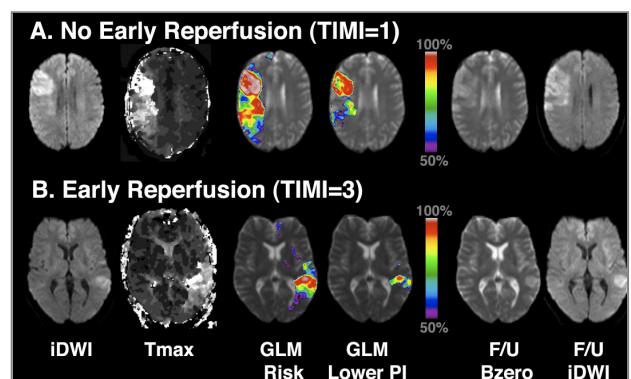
Example input and output GLM maps for patients receiving rt-PA who did not reperuse (A) and who did reperuse (B). Note the much larger PLV for (A) who did not reperuse compared to (B) despite having a larger PWI and DWI mismatch. A larger lesion volume on the lower 95% PI can also be observed in (A) compared to (B), suggesting presence of more severely injured tissue.
